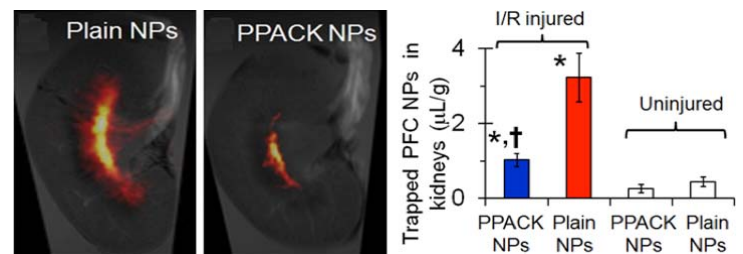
Acute Kidney Injury Model: PPACK PFC NPs Inhibit Coagulation and Microangiopathy in AKI. Left: Ex vivo ^{19}F MRI of kidney coregistered with ^1H anatomic image. Right: Ex vivo ^{19}F quantification of trapped PFC NP due to coagulation
